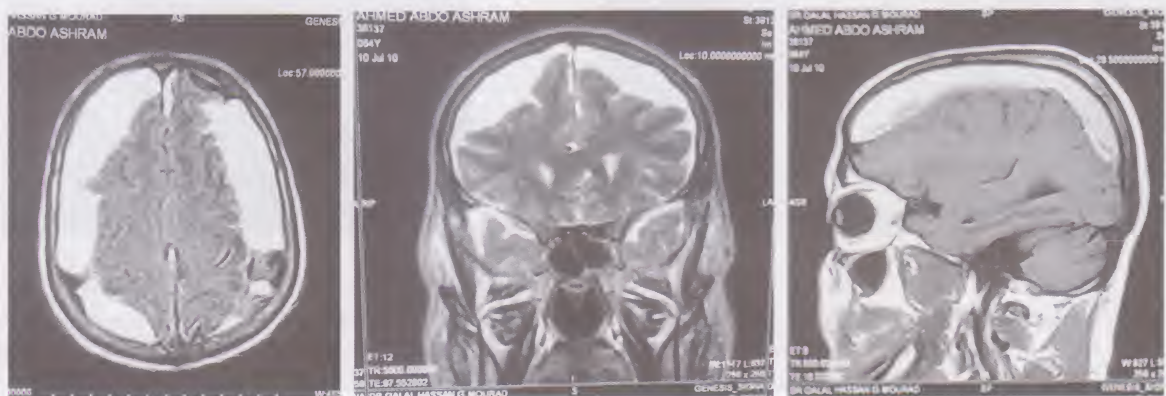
Axial, coronal, and sagittal MRI views (from left to right respectively) showing bilateral subdural hematoma
